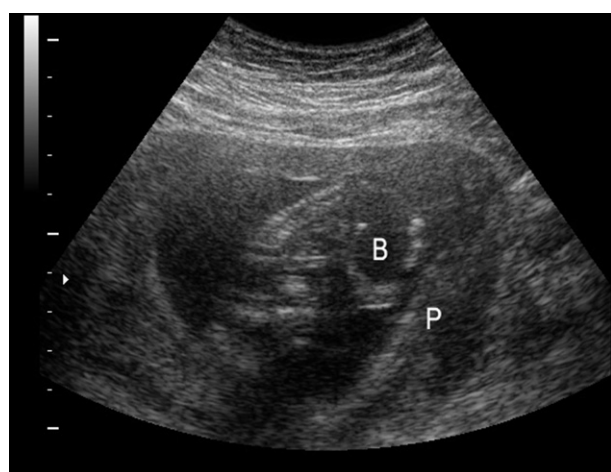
Prenatal ultrasound at 14 weeks of gestation showing abdominoplacental attachment and megacystis but no scoliosis. B = bladder; P = placenta.
